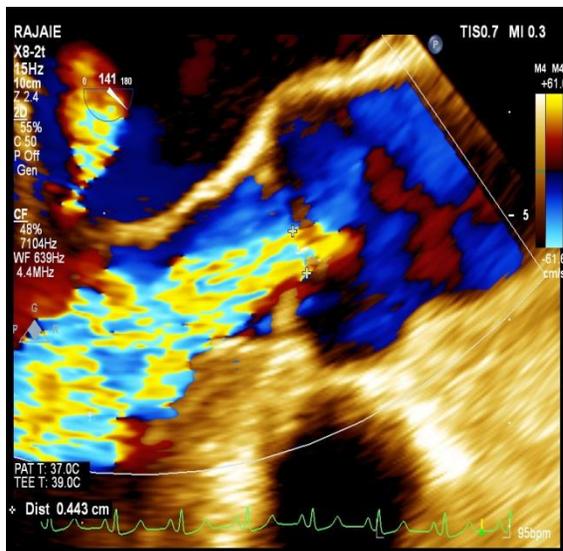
The image presents a zoomed view of aortic regurgitation in transesophageal echocardiography.
